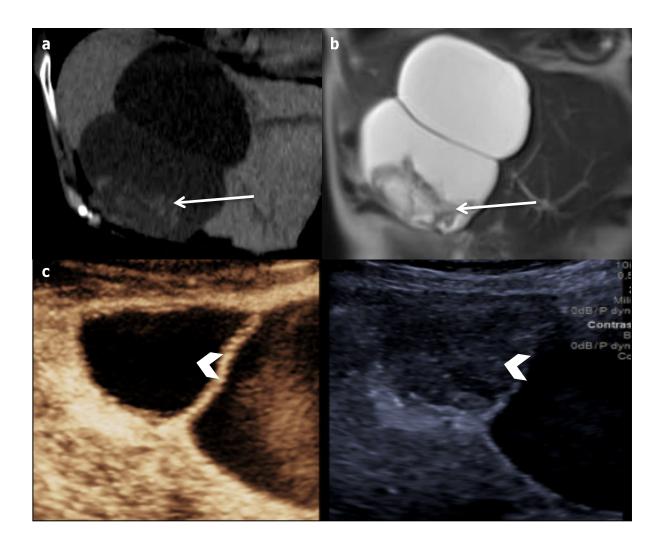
Bilobulated haemorrhagic hepatic cyst in a 73-year-old female patient. (a) Coronal non-enhanced computed tomography shows a bilobulated cyst with spontaneous declive hyperattenuation (arrow); (b) Coronal T2-weighted magnetic resonance imaging shows a declive heterogeneous hypointensity inside the inferior part of the cyst (arrow). (c) Contrast enhanced ultrasonography confirms the non-enhancement of the cystic part of the lesion (arrowhead).
